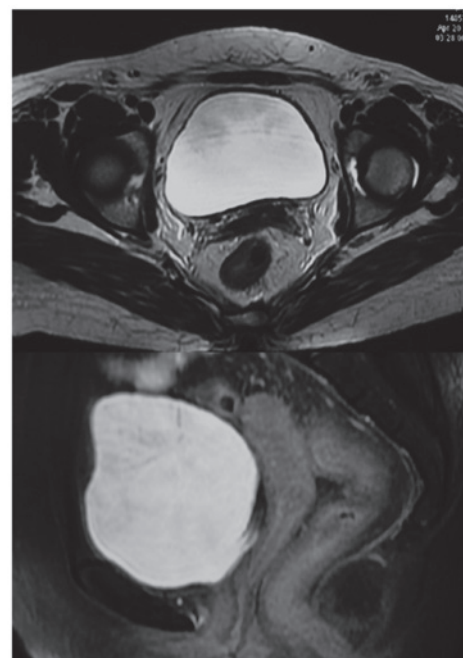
Post-NDLS chemotherapy MRI of abdomen: No evidence of residual mass in the cervix or enlarged internal iliac or paraaortic lymph nodes.
